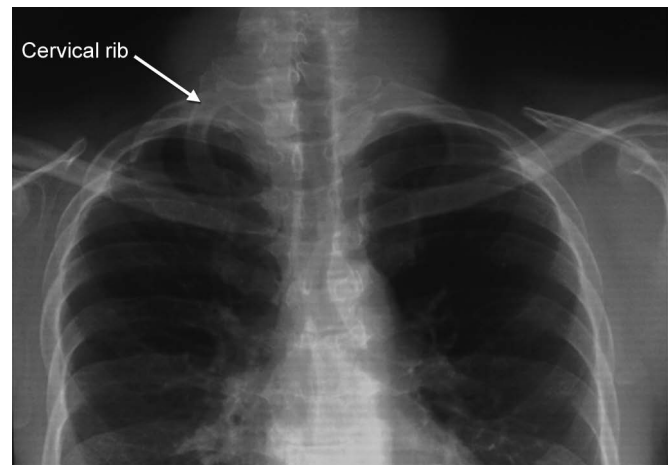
X-ray showing cervical rib on right side.
